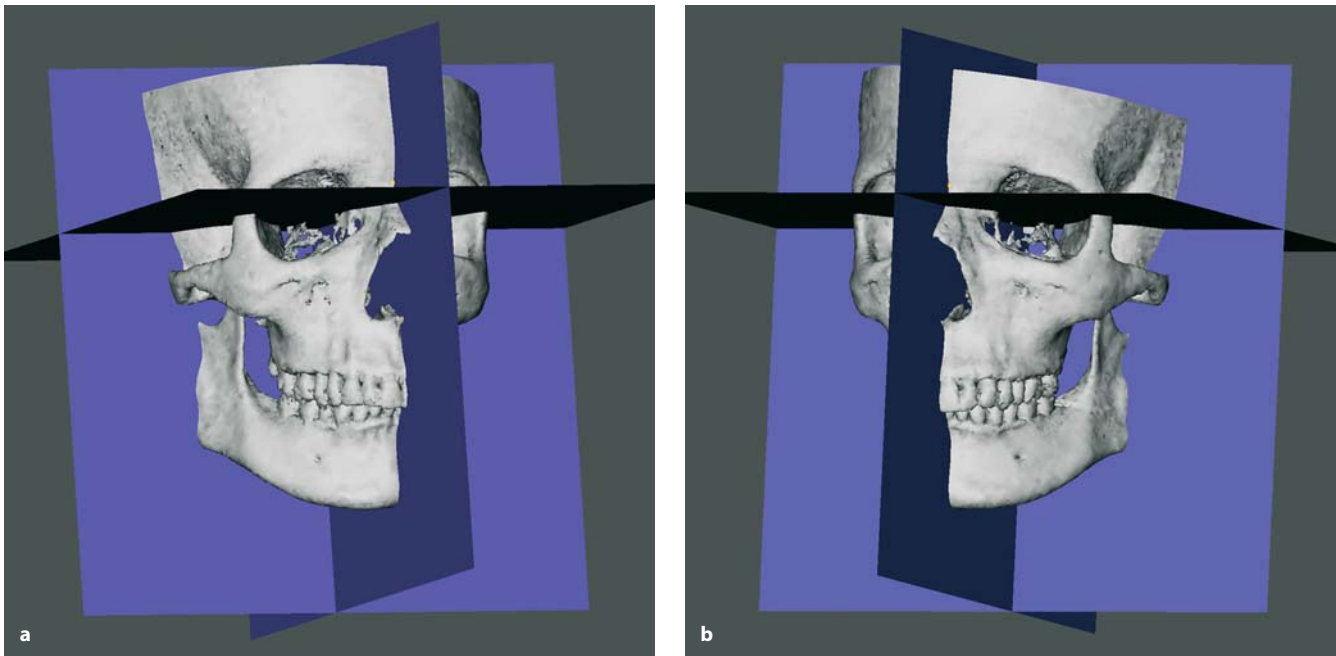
a, b. 3-D cephalometric reference system superimposed on the hard tissue surface representations (3-D CT, patient K.C.)
